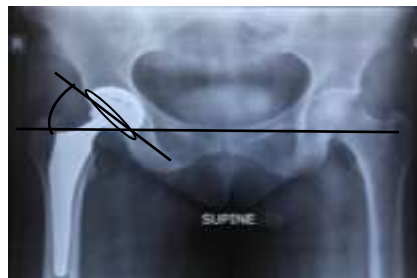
Anteroposterior pelvic x-ray showing Right cement less Total hip prosthesis, with measurement of the cup abduction angle which is the angle between longitudinal axis of the ellipse (L) and the horizontal interteardrop line.
